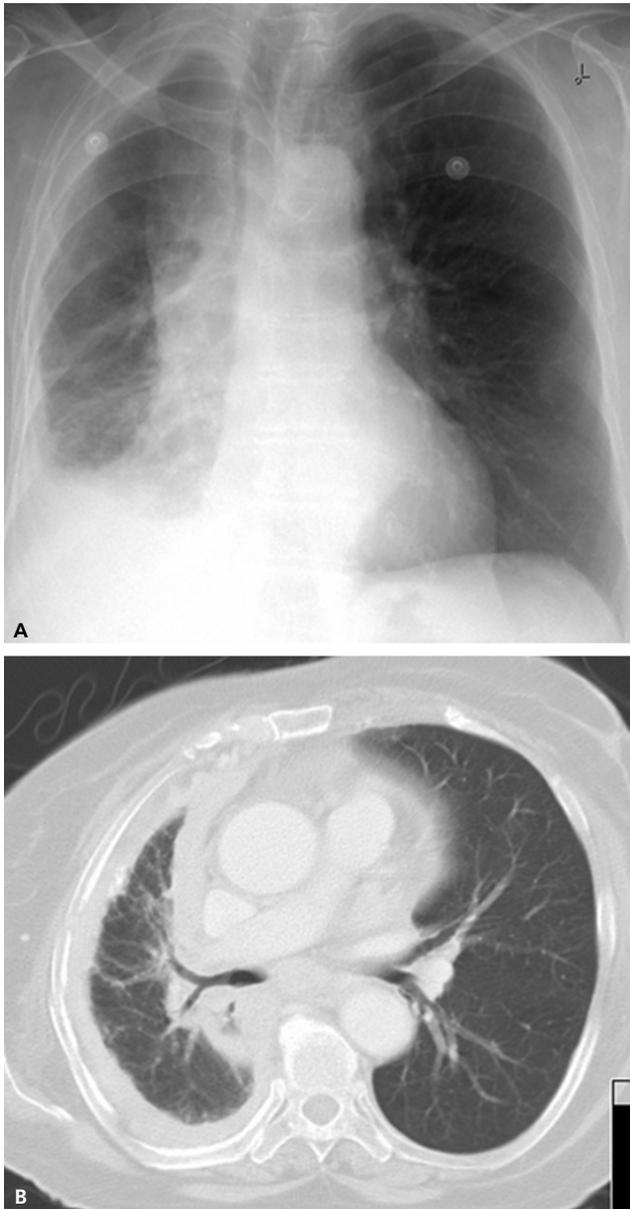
(A and B) Posterior-anterior chest X-ray and TCT showing regression of mediastinal lymph nodes and pleural nodules after chemotherapy containing pemetrexed.
